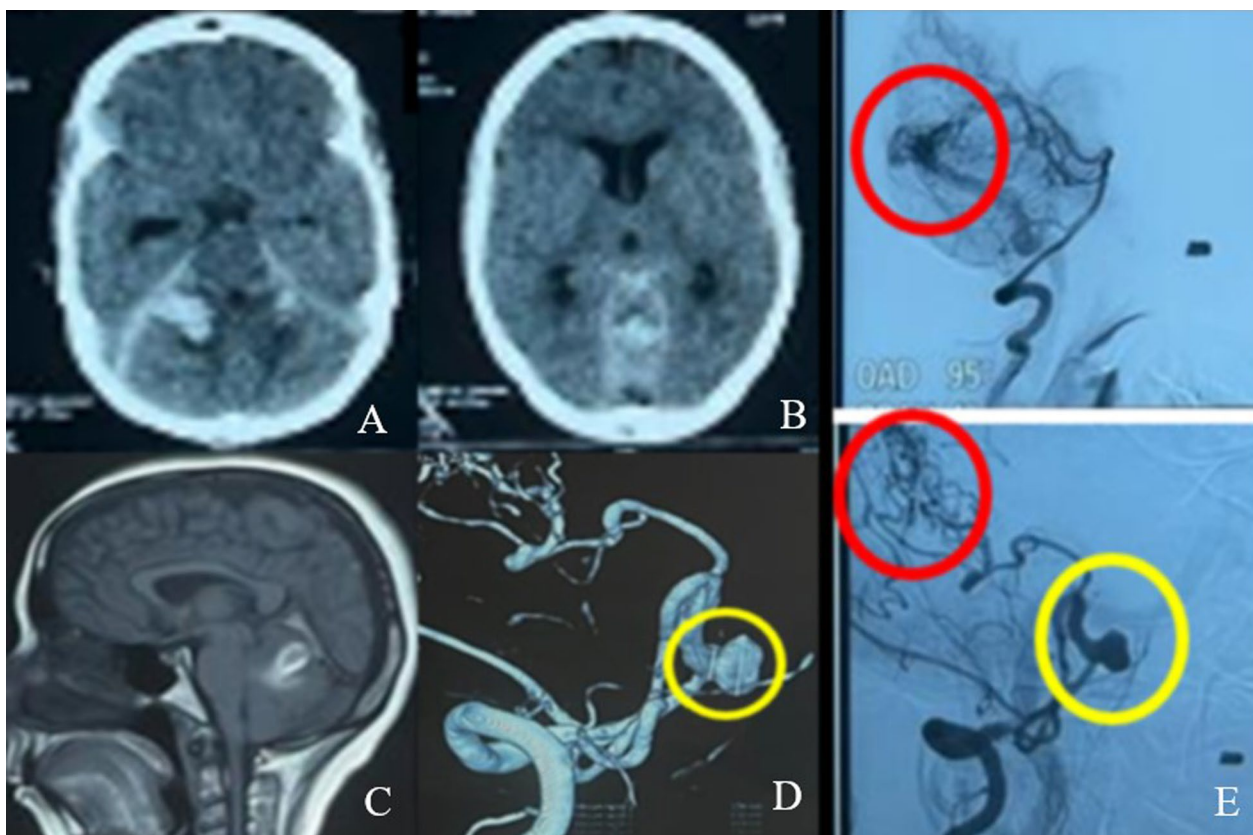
A–B–C: Cerebral CT and MRI showing a cerebellar hematoma with subarachnoid hemorrhage D–E: DSA shows a posterior fossa AVM feed by the right PICA. Venous drainage towards the torcular and a large flow related PICA aneurysm
